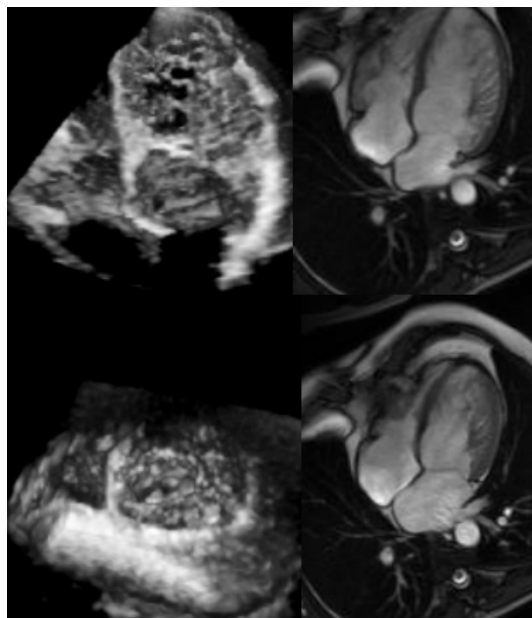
Several images from a patient with noncompaction cardiomyopathy: apical four-chamber (top left) and short-axis (bottom left) views on three-dimensional echocardiography, and apical four-chamber views at end-diastole (top right) and end-systole (bottom right) on cardiac magnetic resonance imaging.
